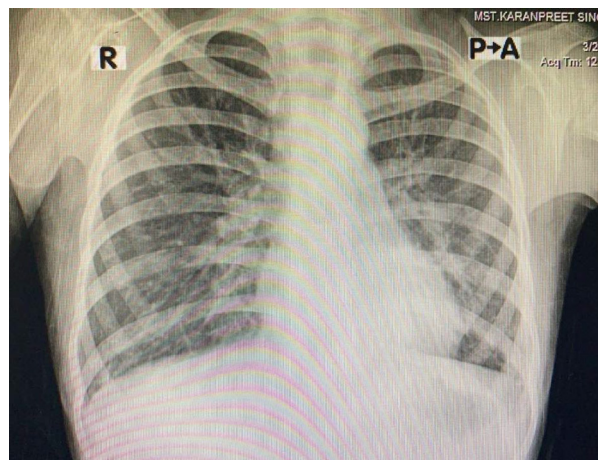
Follow-up chest radiography showing complete resolution of opacities
